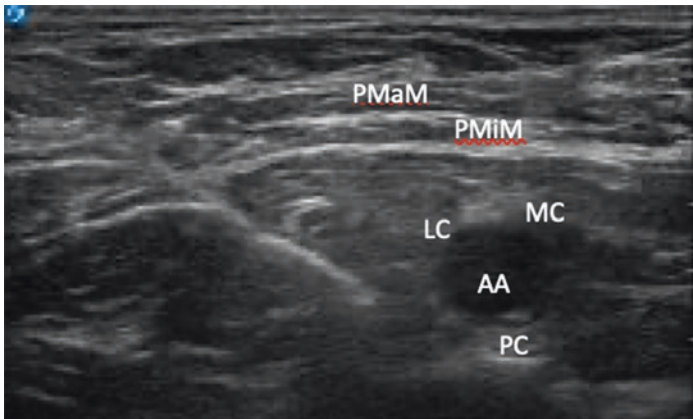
Infraclavicular block, ultrasound image. Brachial plexus surrounding axillary artery at the level of cords. AA axillary artery, MC medial cord, PC posterior cord, LC lateral cord, PMaM pectoralis major muscle, PMiM pectoralis minor muscle
